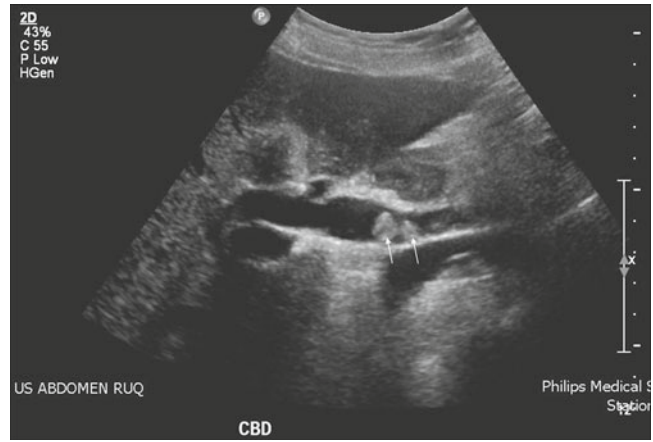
A 67-year-old woman with a history of previous cholecystectomy has recurrent symptoms of biliary colic. Right upper quadrant ultrasound sagittal image shows a dilated CBD (common bile duct) with two round stones (*white arrows*), confirming stones in the CBD (choledocholithiasis). Diagnosis: Choledocholithiasis
